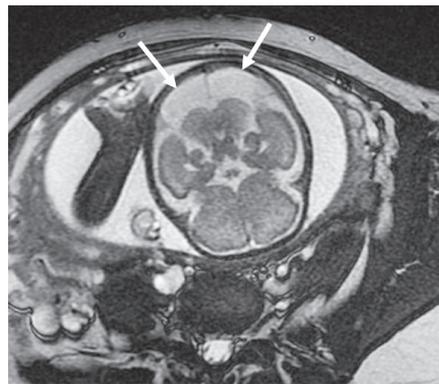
Case 7: (a) Antenatal MRI shows megacisterna magna (arrows) in a 30-week fetus while (b) postnatal MRI done 3 weeks after birth shows a posterior fossa arachnoid cyst (arrowheads). Baby was developmentally normal at 2 months.
